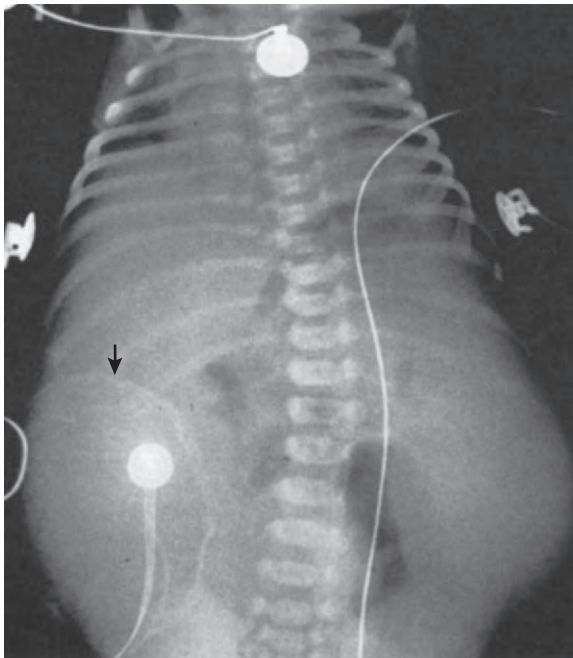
Abdominal radiograph of meconium peritonitis with a giant pseudocyst demonstrating calcification (arrow) in the cyst wall. (From Ashcraft KW, Holder TM [eds]: *Pediatric Surgery*. Philadelphia, WB Saunders, 1999.)
